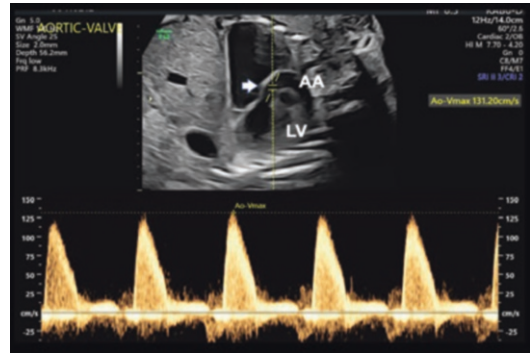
Duplex Doppler interrogation. Top: Spectral Doppler flow image of the fetal ascending aorta (AA). LV = left ventricle. The vertical line is the cursor representing the beam path. The Doppler sample volume (two short horizontal lines, white arrow) is placed in AA just distal to the aortic valve. Bottom: Doppler shifts from AA. The left and right margins of the Doppler panel show the blood flow velocity scale in centimeters per second. The peak systolic velocity (131.20 cm/s) is shown in the upper panel
